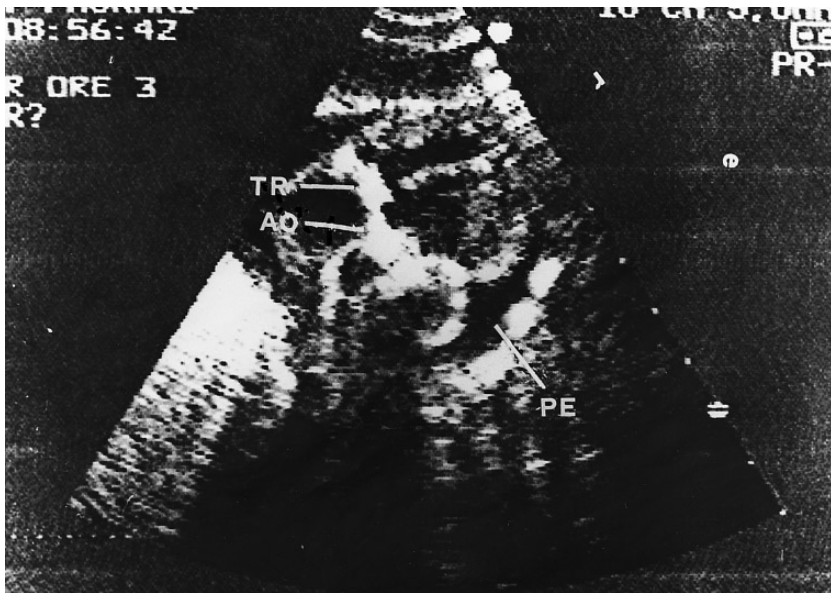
Echocardiogram at 1 day of age showing marked hyperechogenicity of the aorta (AO) and tricuspid valve (TR) with a pericardial effusion (PE).
